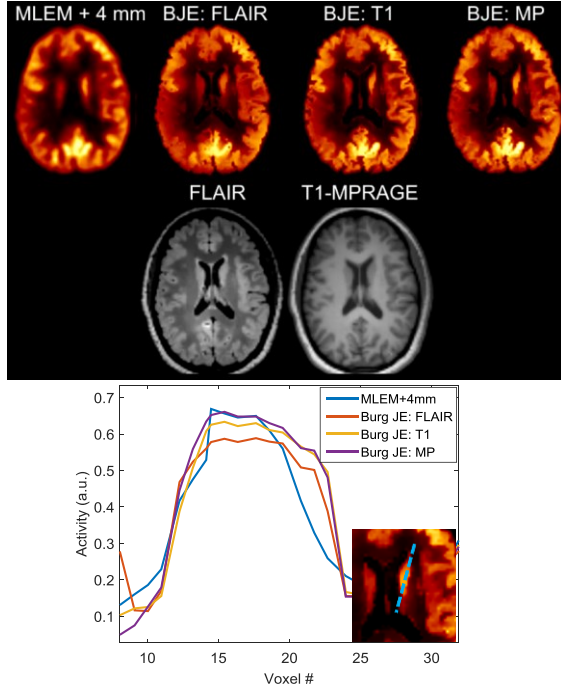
The reconstruction results of the clinical FDG dataset using the proposed approximate joint entropy prior employing FLAIR, T1 MRI data and multi-parametric T1-FLAIR-PET (MP) data during reconstruction.
